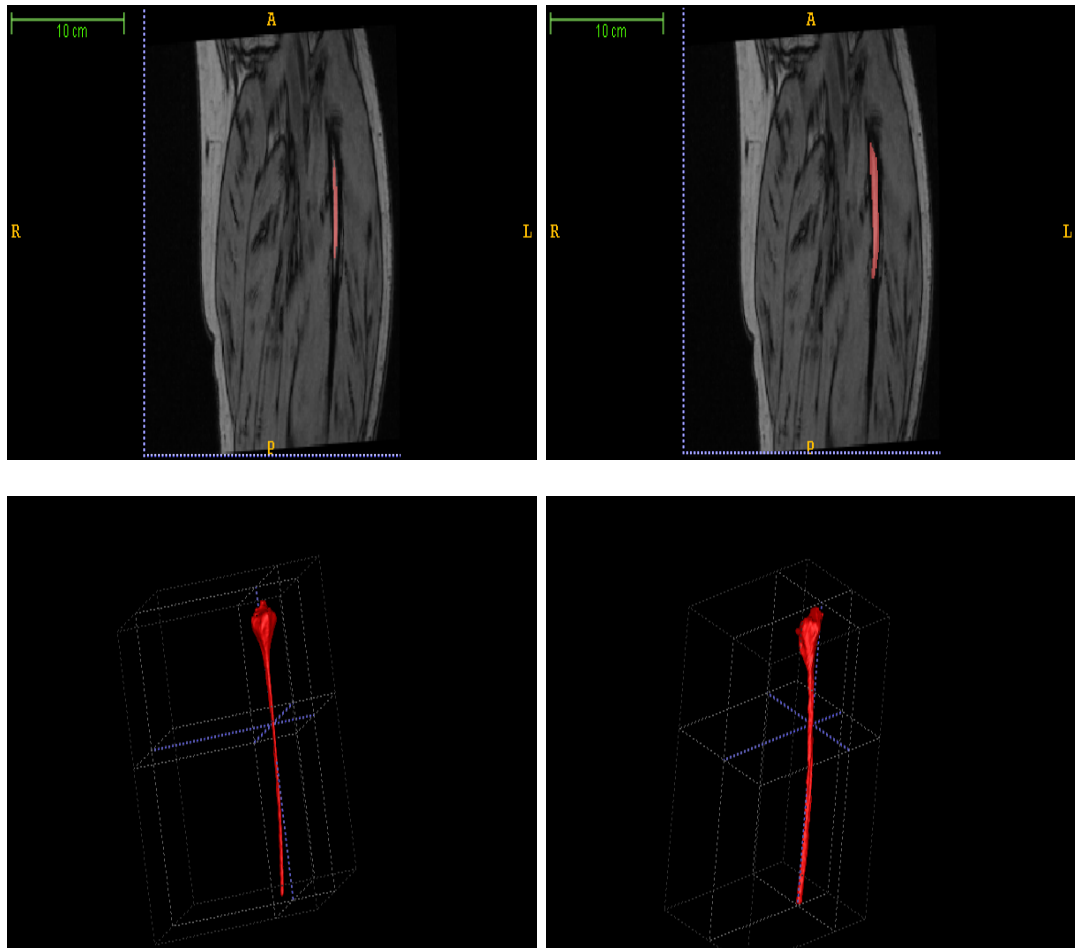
Segmentation of fibula (shown in red) on T1 weighted MRI are shown in 2D sagittal slices and 3D volume. Left column shows the result of our employed segmentation method, right column shows the result of manual segmentation for comparison. We can see that our segmentation method gives similar result to that of manual segmentation.
